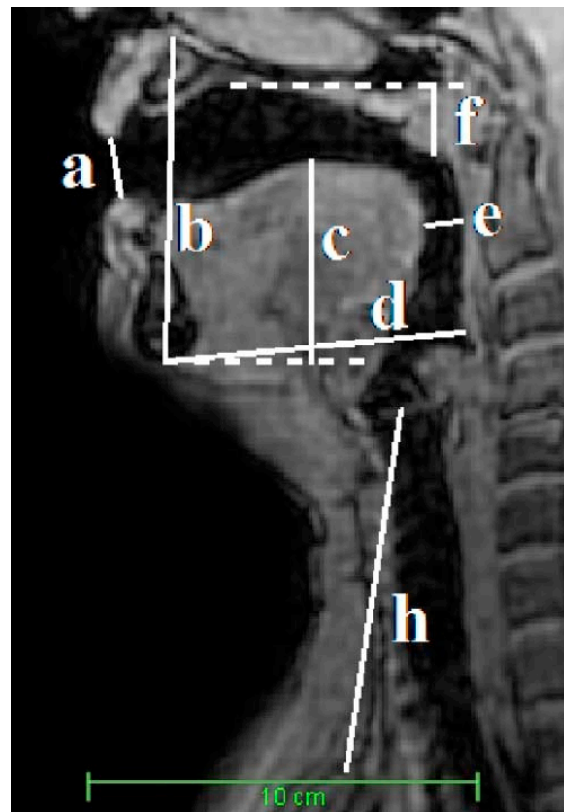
Two-dimensional magnetic resonance imaging measurements: (a) lip opening, (b) jaw opening, (c) height of the tongue dorsum, (d) jaw protrusion, (e) oropharynx width, (f) uvula elevation, and (h) larynx height. (g) Oropharynx breadth, (i) lip spreading, and (j) vocal tract length are not shown.
